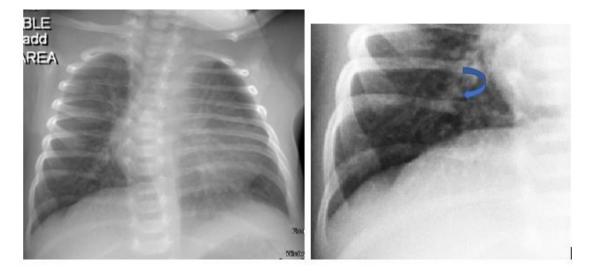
Chest radiograph (A full chest, B magnified part of Rt lower lung zone) representing accentuated hilar shadows with prominent vascularity, with fine beaded appearance (curved arrow) mainly basal and parietal with prominent fine linear interstitial shadowing appearance denoting mild severity of chest involvement in patient with positive PCR for Covid 19 and presenting with mild clinical manifestation.
